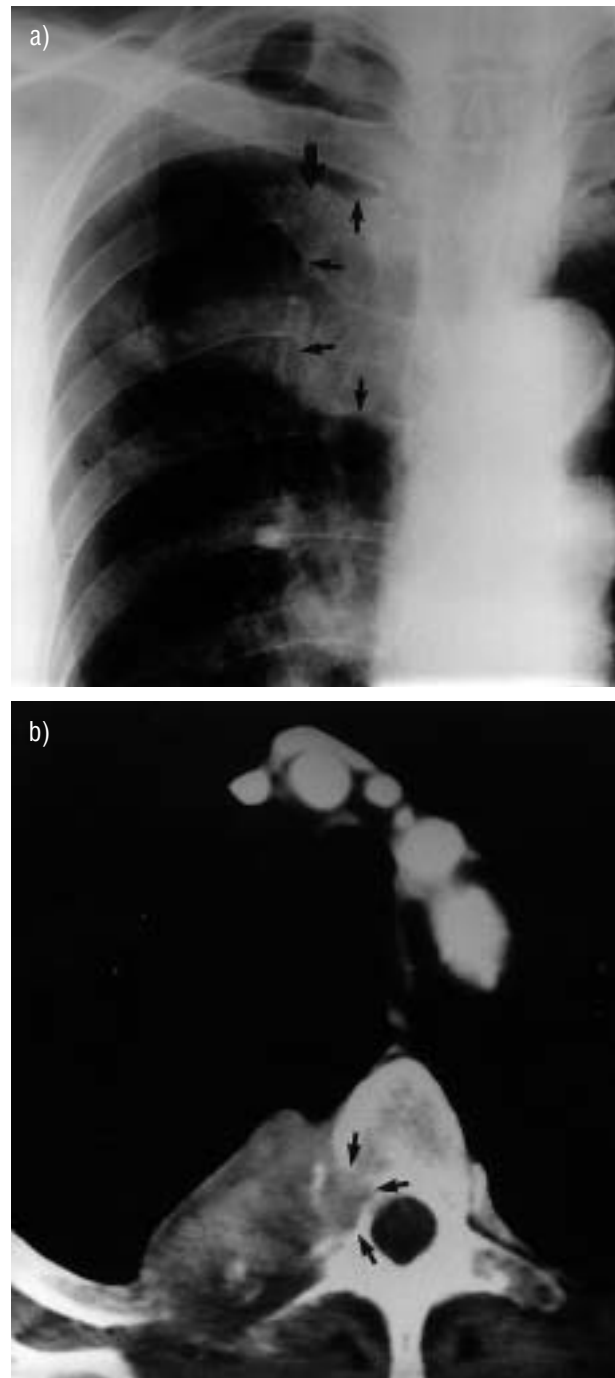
a) Rib erosion (large arrow) due to peripheral tumour (small arrows) suggesting at least T3 disease. b) Corresponding computed tomography showing mass eroding rib and vertebral body (arrows) confirming T4 status and inoperability.
